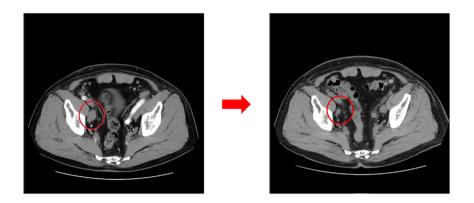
CT images. Left: lymphadenopathy before chemotherapy. Right: lymph node shrinkage after six courses of chemotherapy.
